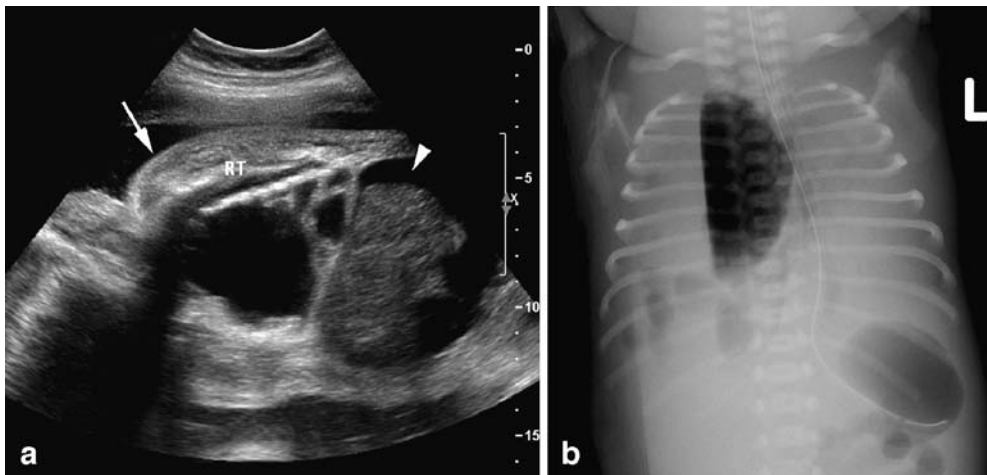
Type I/III CPAM of the lung. a An in utero longitudinal US of the chest at 28 weeks demonstrates multiple large right-side pulmonary cysts occupying most of the chest. Note marked edema of the body wall (hydrops) (*arrow*) and ascites (*arrowhead*). In utero cyst aspiration was performed. The baby was born at 30 weeks by emergency cesarean section. b Right lateral decubitus chest radiograph at birth. In the right lung, there is a single, very large cyst and multiple smaller cysts with air-fluid levels denoting
